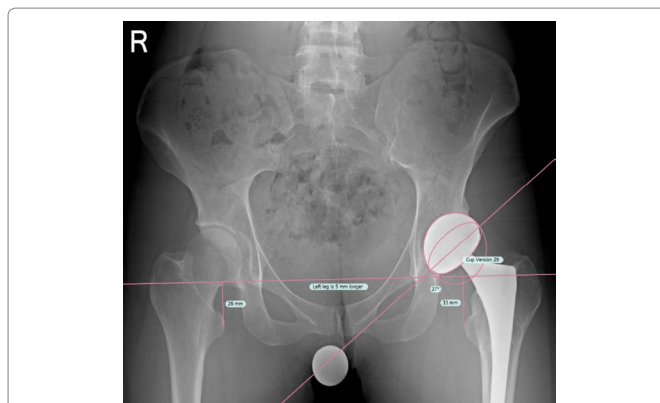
Case 1: Pre-revision anteroposterior radiograph with angular measurements of acetabular component position with 37 degrees of inclination and 29 degrees of anteversion.
